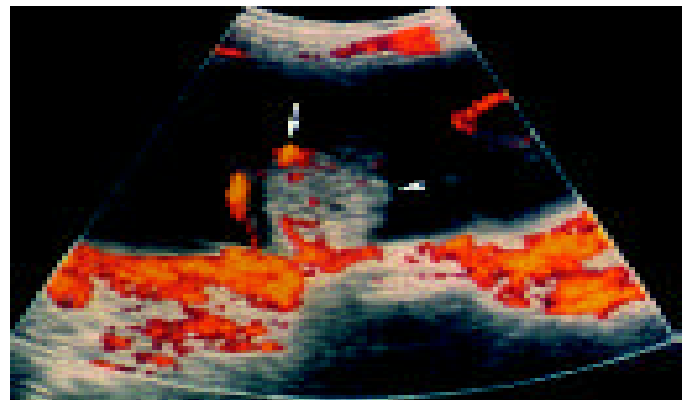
Doppler blood flow characteristics of a malignant adnexal mass.
